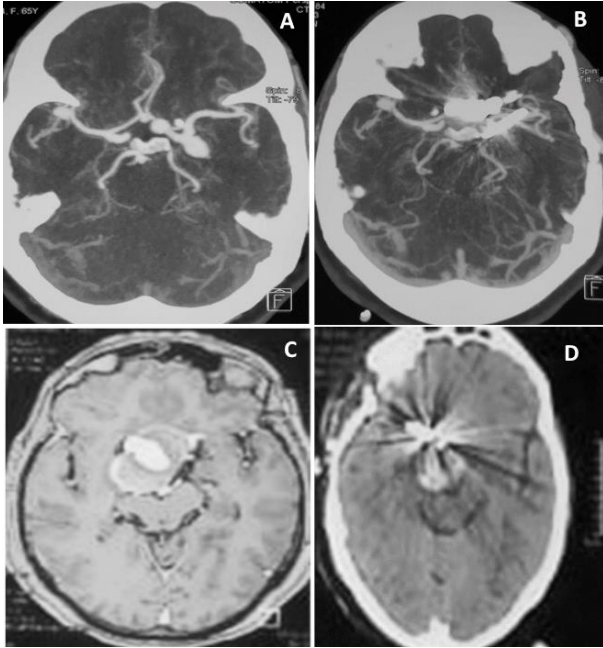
Axial view (A) showing the laterally projecting left PCOM , medially projecting left ophthalmic segment, ACOM and laterally projecting right MCA bifurcation aneurysm and (B) Post op Computed tomography angiography left PCOM, left ophthalmic segment and ACOM aneurysms T1 contrast MRI axial view (C) showing giant atherosclerotic right communicating segment aneurysm and non-contrast computed tomography, Axial view (D) showing post op clip artefact with occlusion of neck.
